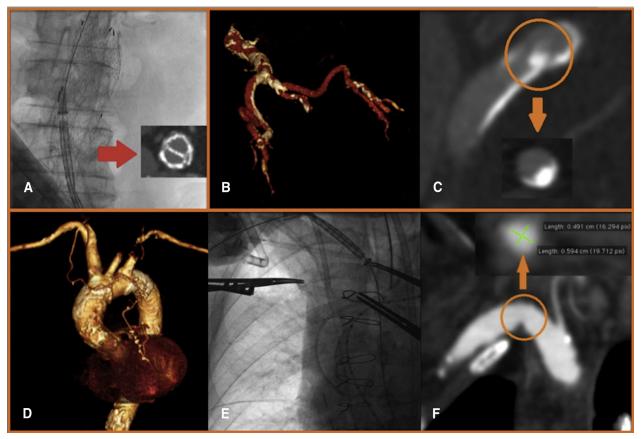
Sheathless femoral transcatheter aortic valve implantation (TAVI) in a patient with aortoiliac endoprosthesis (A) and in a patient with severe calcifications of aortic carrefour (B and C); sheathless right subclavian TAVI in a patient with previous coronary artery bypass grafting, porcelain aorta, diseased femoral and iliac access, occluded left subclavian artery, and small right subclavian artery (D-F). *Arrows* indicate the axial computed tomography scan details. The computed tomography scan vessel diameters are in *green*.
